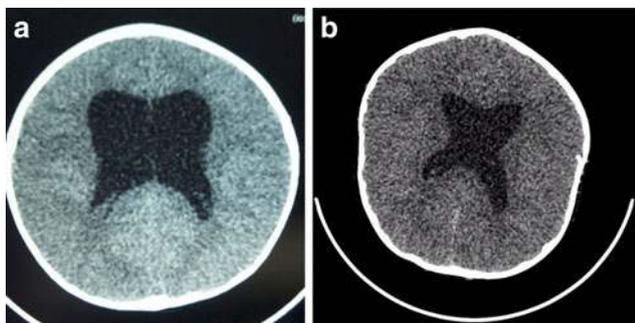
a Axial CT scan showing ventriculomegaly, deficient septum pellucidum, and significant increased intracranial pressure in a male who presented at the age of 3 with Apert syndrome. b Axial CT scan showing ventriculomegaly and an absent septum pellucidum
